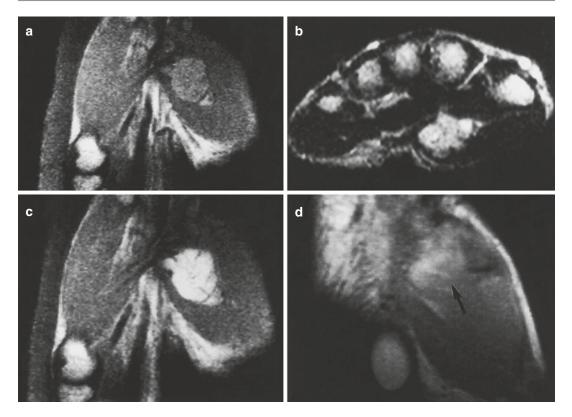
Clear cell sarcoma of the right hand in a 25-year-old woman. (a) Coronal spin-echo T1-weighted MR image. (b) Axial fast spin-echo T2-weighted MR image. (c) Coronal spin-echo T1-weighted MR image after gadolinium contrast injection. (d) Coronal spin-echo T1-weighted MR image after gadolinium contrast injection, performed 6 weeks after initial surgery. The presence of a well-circumscribed mass within the thenar muscle. The mass is slightly hyperintense relative to muscle on native T1-weighted images (a). On T2-weighted images, signal intensity is high. There is no peritumoral edema (b). Following gadolinium contrast injection, strong homogeneous enhancement is seen (c).
